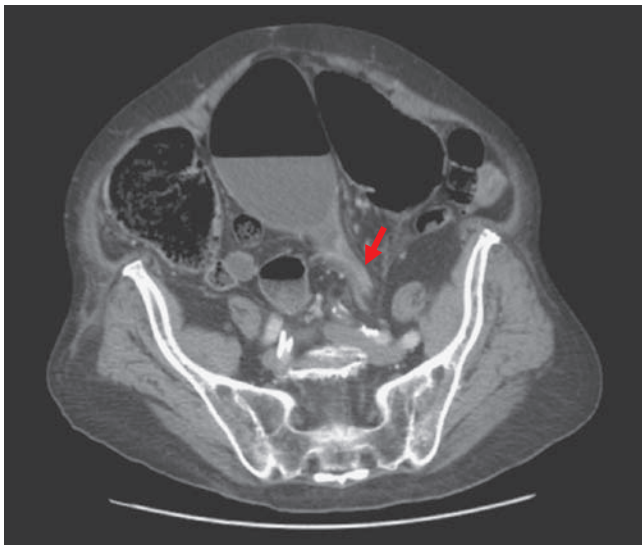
Transverse CT scan section showing beaking at site of sigmoid volvulus.
